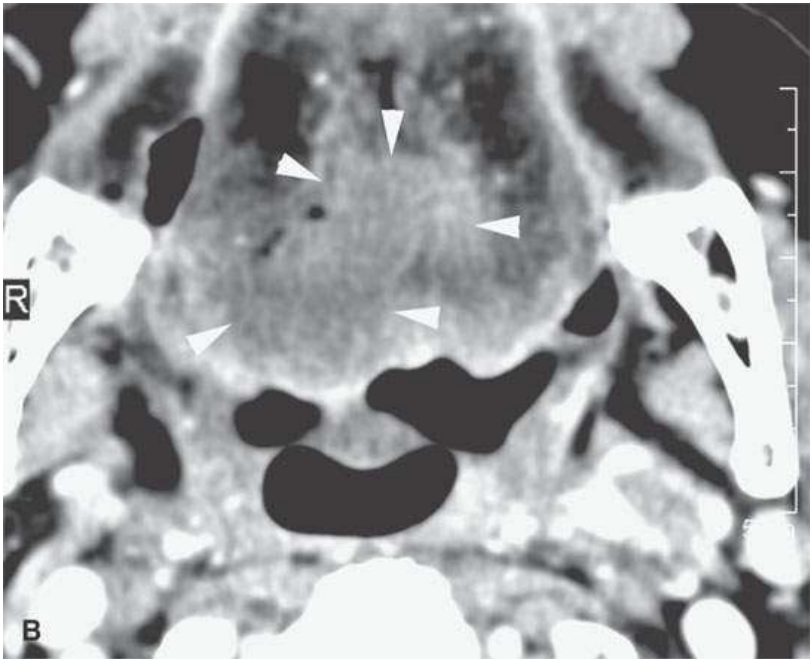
Contrast-enhanced computed tomography of a tonsillar carcinoma within some areas of hard to define margins and carotid artery encasement (arrowheads) as an example on a tumor with infiltrative and pushing margins combined.
